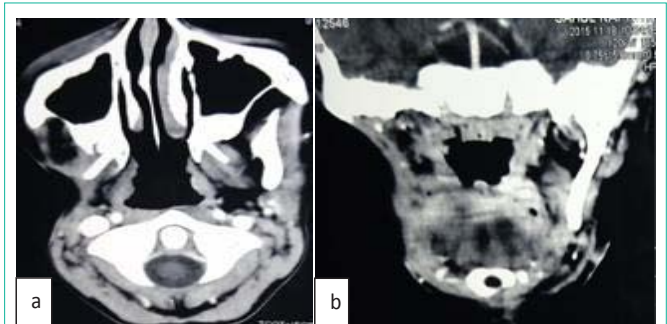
a,b) Coronal and Axial view of CT scan taken one year post operatively showing complete clearance of lesion with no evidence of recurrence.
